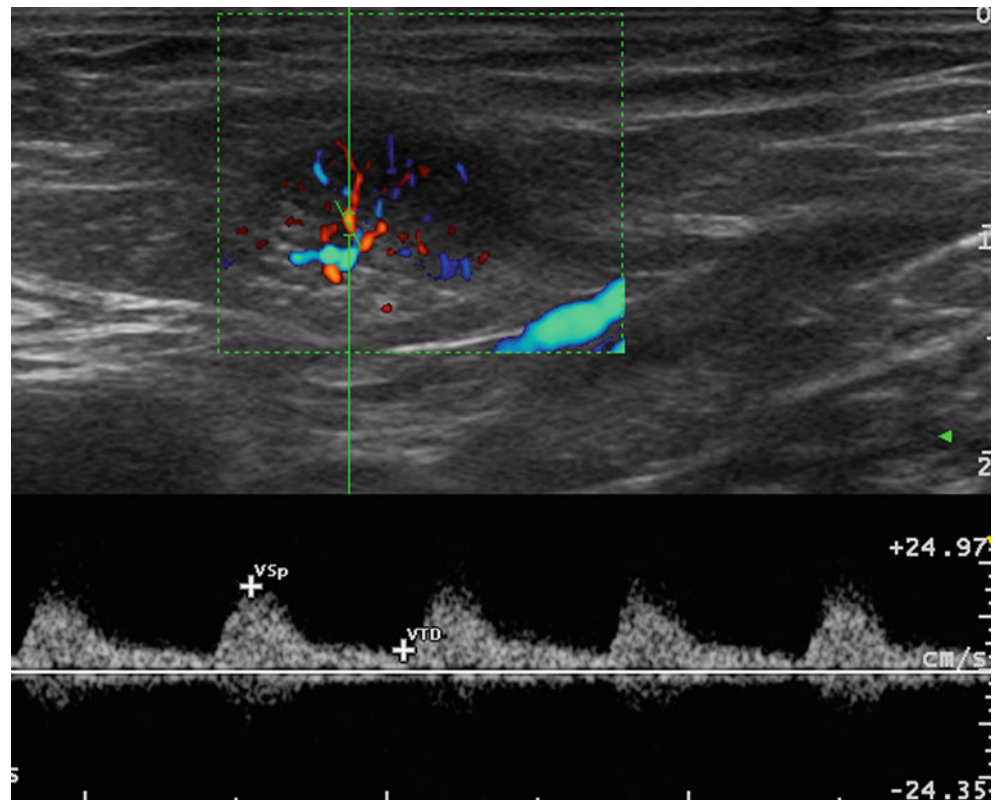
Spectral analysis of a metastatic inguinal lymph node. The flowmetry below the directional power Doppler image depicts a moderate raise in flow speed (16 cm/s peak systolic flow) and flow resistance (0.75 resistive index)
